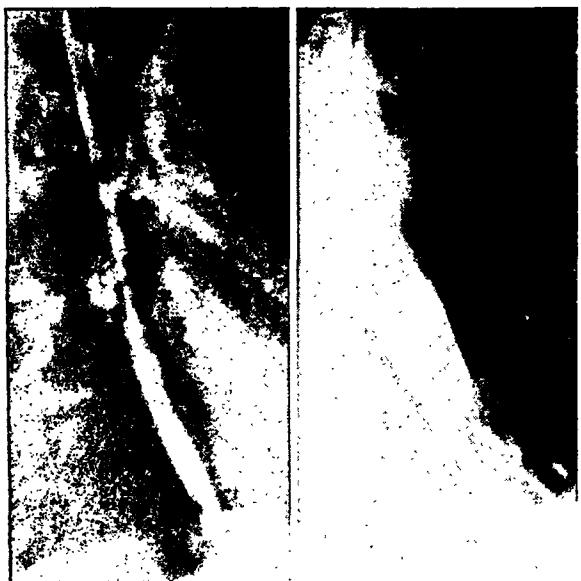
Case 1: Roentgenograms made Oct. 13, 1941.
